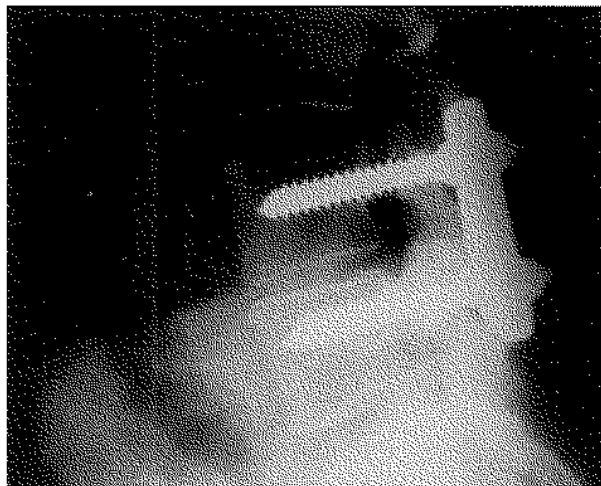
Lateral radiograph of a single level dorsal fusion (L₄-L₅), fixed by the "Variable Screw Placement Spinal Fixation System". The bone graft is located around and underneath the plate, in case of a posterior lateral fusion (P.L.F.).
